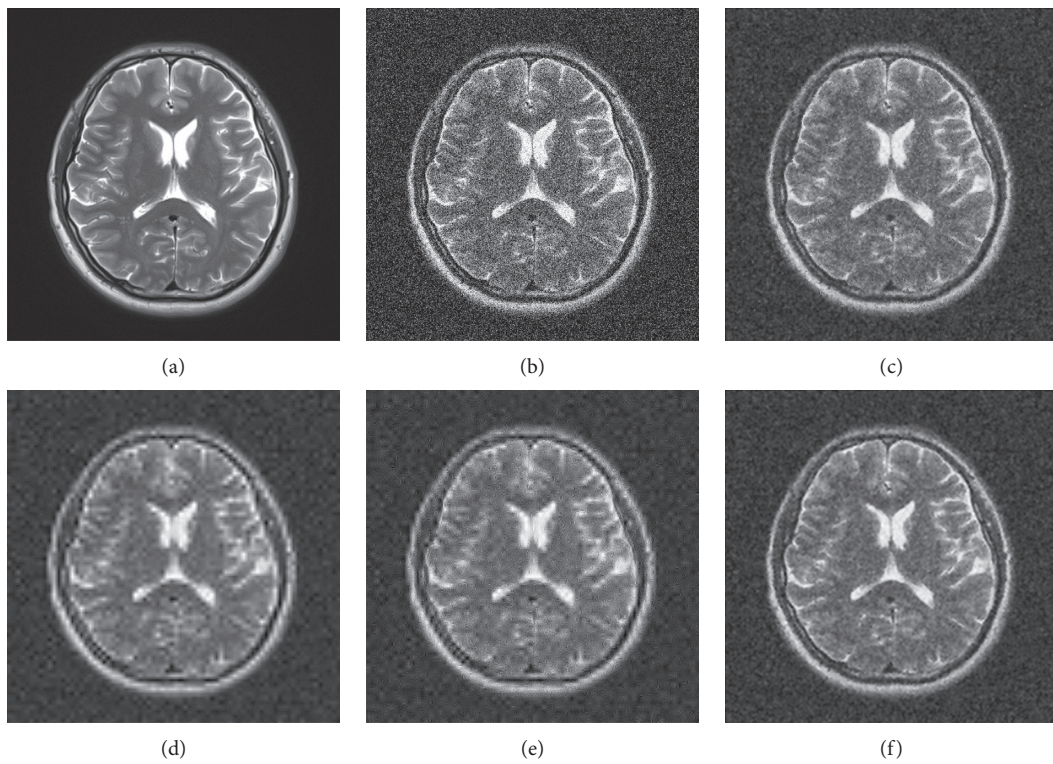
Subjective denoising results of MRI 3 in different ways. (a) Original image, (b) noisy image, (c) Wiener filter, (d) hard threshold, (e) soft threshold, and (f) proposed.
